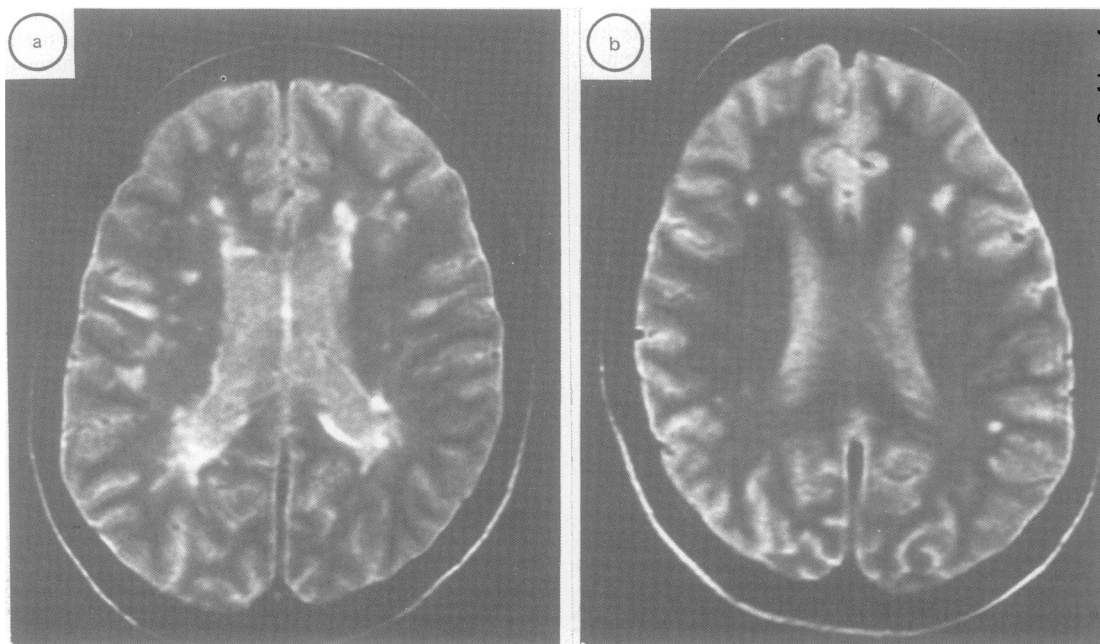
Fig MR images demonstrating white matter abnormalities in both members of a monozygotic twin pair (a: patient, b: non-patient).
